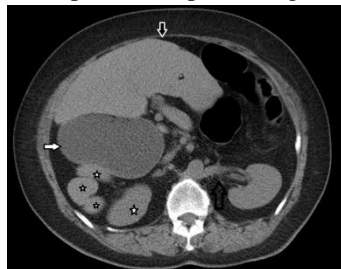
Axial section non-contrast CT showing the midline-located liver (black arrow), multiple spleens (stars), right-sided stomach (white arrow), and retroaortic left renal vein (empty arrow)
